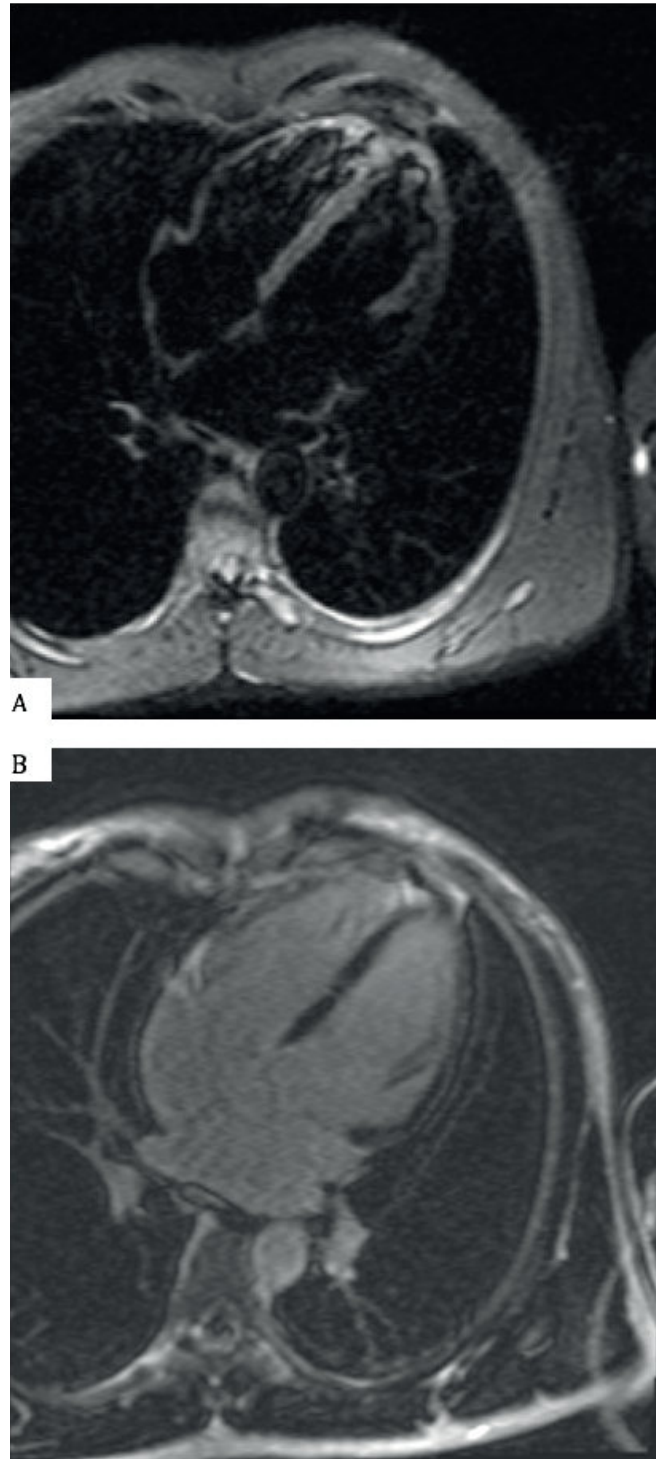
Cardiac MRI. Figure 2A – Four chamber cardiac MRI showing interventricular septum with rough compounds (black arrows), with thickness of 10mm. Thinned interventricular septum is in the middle of LV (white arrows). Figure 2B – Post-contrast T1-weighted delayed mid-wall septal hyperenhancement (white arrows).
